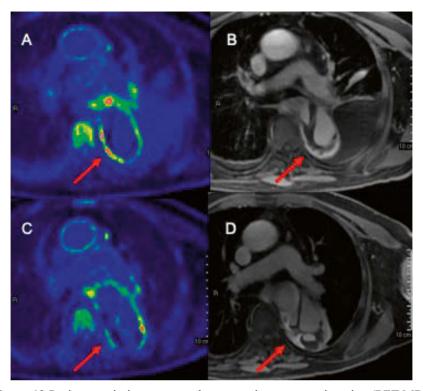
Positron emission tomography magnetic resonance imaging (PET MRI) characteristics in a patient with acute type B aortic dissection in different phases of an acute type B dissection; A+B) acute phase <14 days showing FDG uptake (upper left arrow) and gadolinium enhancement (upper right arrow); C+D) subacute phase 3-4 months decreasing FDG uptake (lower left arrow) and gadolinium enhancement (lower right arow)
